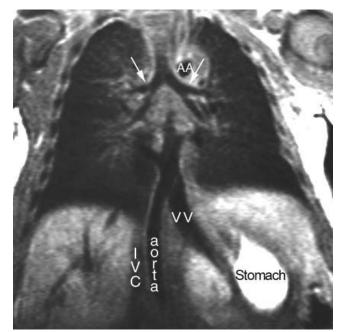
Symmetric bronchial branching in right isomerism. T1weighted MR image in a coronal plane demonstrates bilaterally short main bronchi (arrows). Neither right nor left pulmonary artery is seen above the bronchi. The aorta and inferior vena cava (IVC) are juxtaposed on the same side of the spine. There is infracardiac type of total anomalous pulmonary venous connection through a vertical vein (VV). AA, aortic arch.
